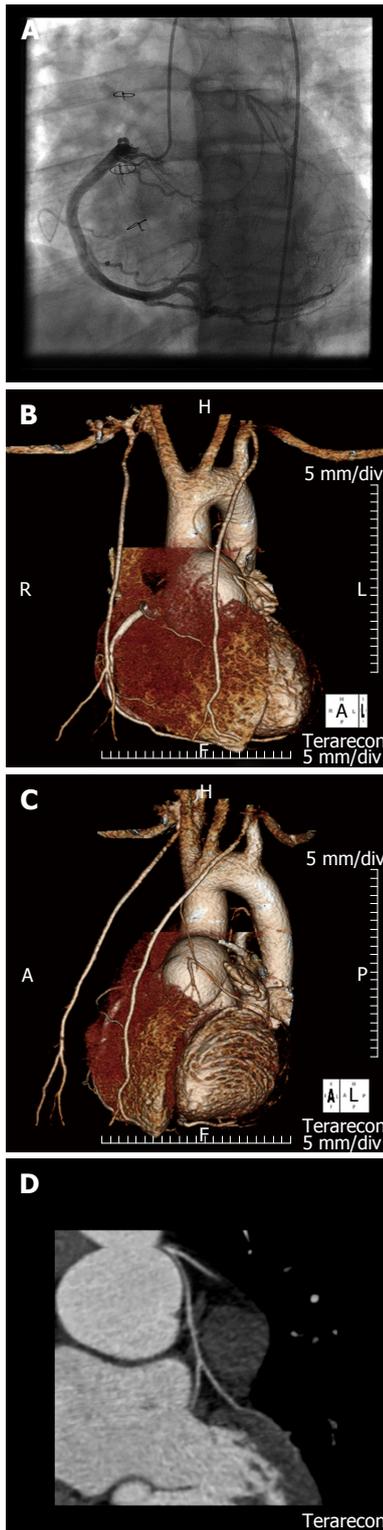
Conventional and computer tomographic coronary angiogram in a 15-year-old patient with infero-lateral ST segment changes on exercise stress test following arterial switch operation for complete transposition of the great arteries. Aortic root injection at catheterization demonstrates retrograde filling of the completely occluded LMCA from ample collaterals vessels from the right (A). CT angiographic views of the antero-posterior (B), left anterior oblique (C) and coronary views (D) indicates ostial occlusion and hypoplasia of the LMCA with collateralization from at the enlarged right coronary artery. CT: Computed tomogram; LMCA: Left main coronary artery.
